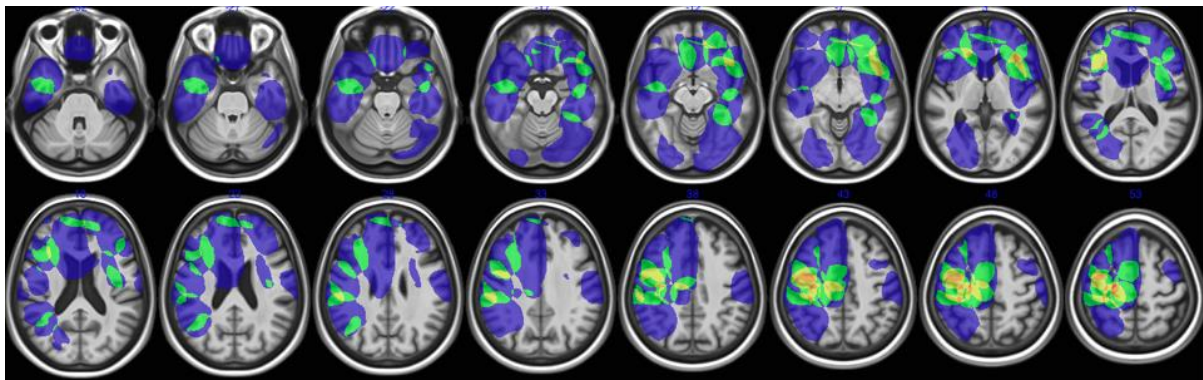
Lesion overlap map for all tumour patients⁷ showing axial slices on a standard Template (Rorden et al. 2012) at MNI Z coordinates: -32, -27, -22, -17, -12, -7, 3, 13, 18, 28, 33, 38, 43, 48, 53. Red = overlap between five individuals; Orange = overlap between four individuals, yellow = overlap between three individuals; green = overlap between two individuals, blue = no overlap, lesion is specific to only one individual. This map was created from T1-weighted structural images collected at 1.5 Tesla. The lesions were segmented manually onto a $1 \times 1 \times 1 \text{mm}$ T1-weighted structural image using MRICron (Rorden et al., 2007), consulting the T2-weighted FLAIR image for additional guidance. Subsequently, the scans and the lesion maps were normalised in SPM8 (Ashburner et al., 2012) using the unified segmentation normalization algorithm from Rorden et al. (2012) and then superimposed onto a standard template.
